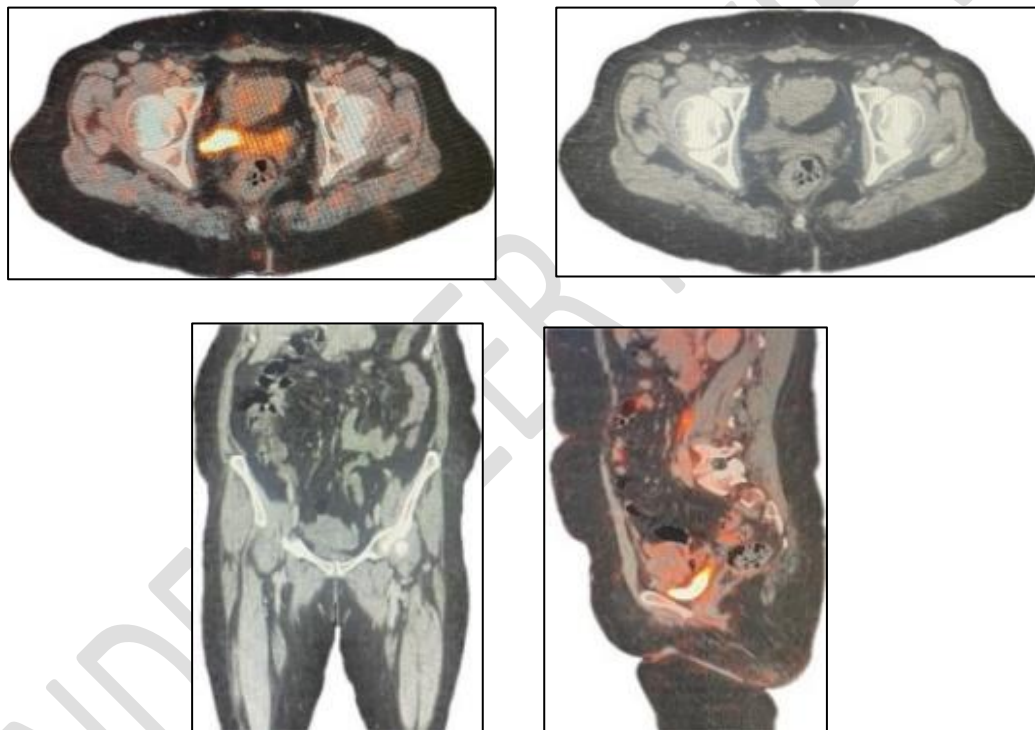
PET-CT scan images prior to exploratory laparotomy
